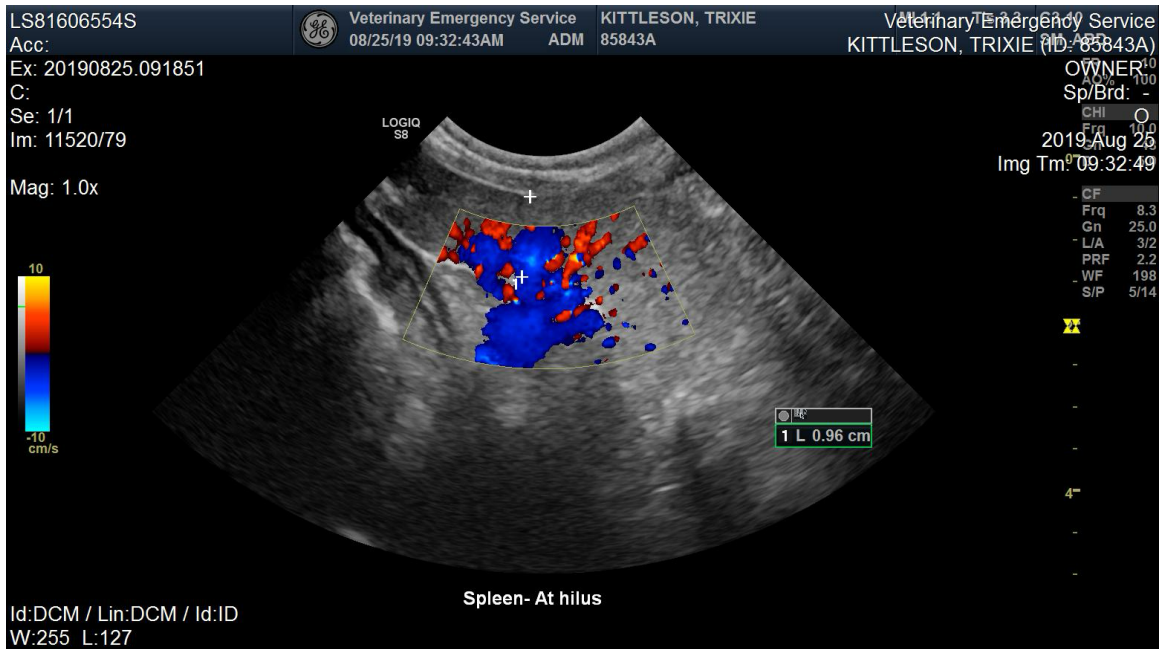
Sagittal view of the spleen at the hilus. Doppler color flow of the hilus does not reveal evidence of a thrombus.
